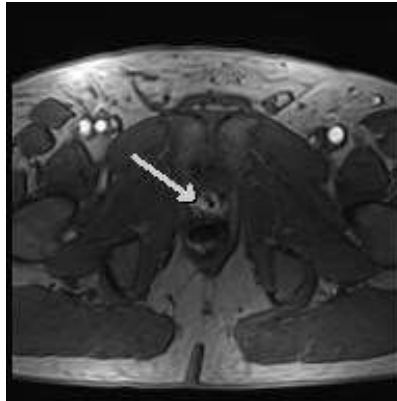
Axial dynamic contrast-enhanced MRI image showing tumour recurrence at vesicourethral anastomosis in patient BCR004 (white arrow).
